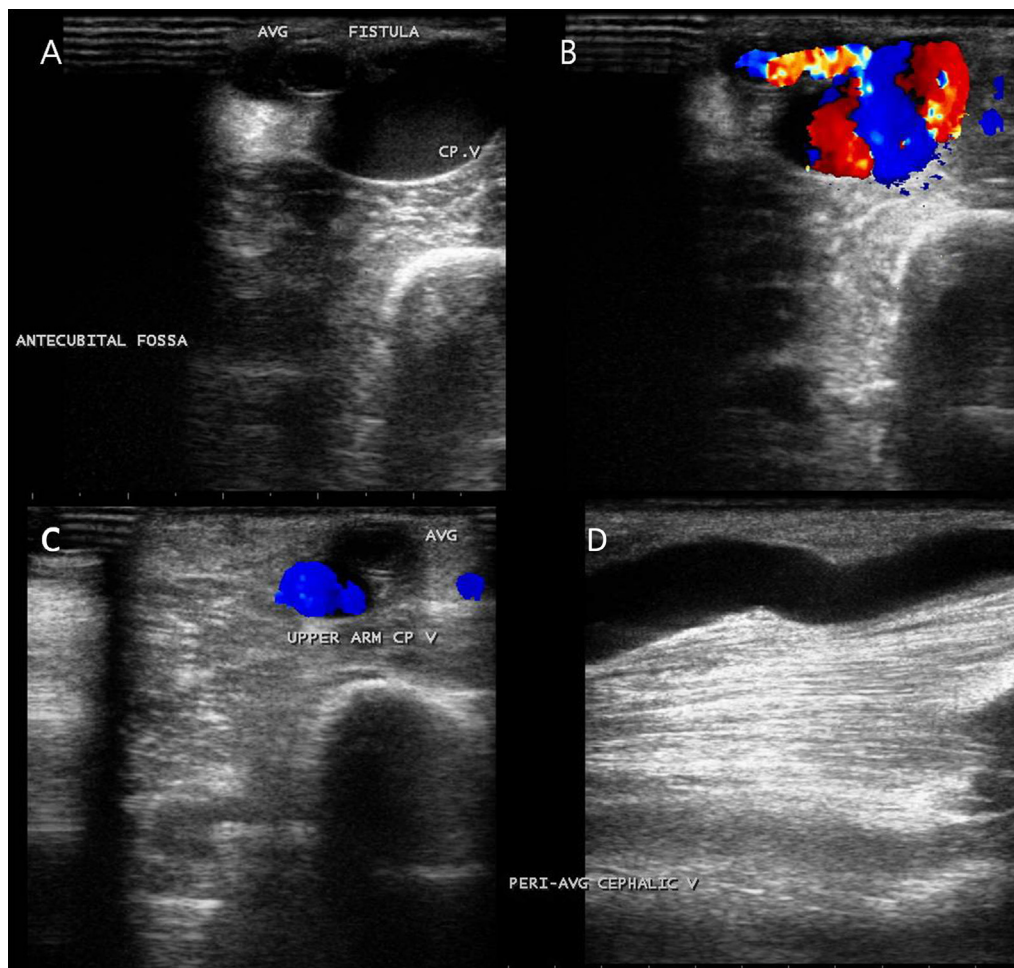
Doppler US findings. (A) Doppler US reveals that the cephalic vein under the AVG was dilated to 13 mm in the antecubital area. (B) It shows blood flow from the AVG to the cephalic vein. (C) On the upper arm, there was no flow in the AVG. (D) In the longitudinal image, the postfistula cephalic vein on the upper arm is dilated to almost 6.9 mm in diameter.
